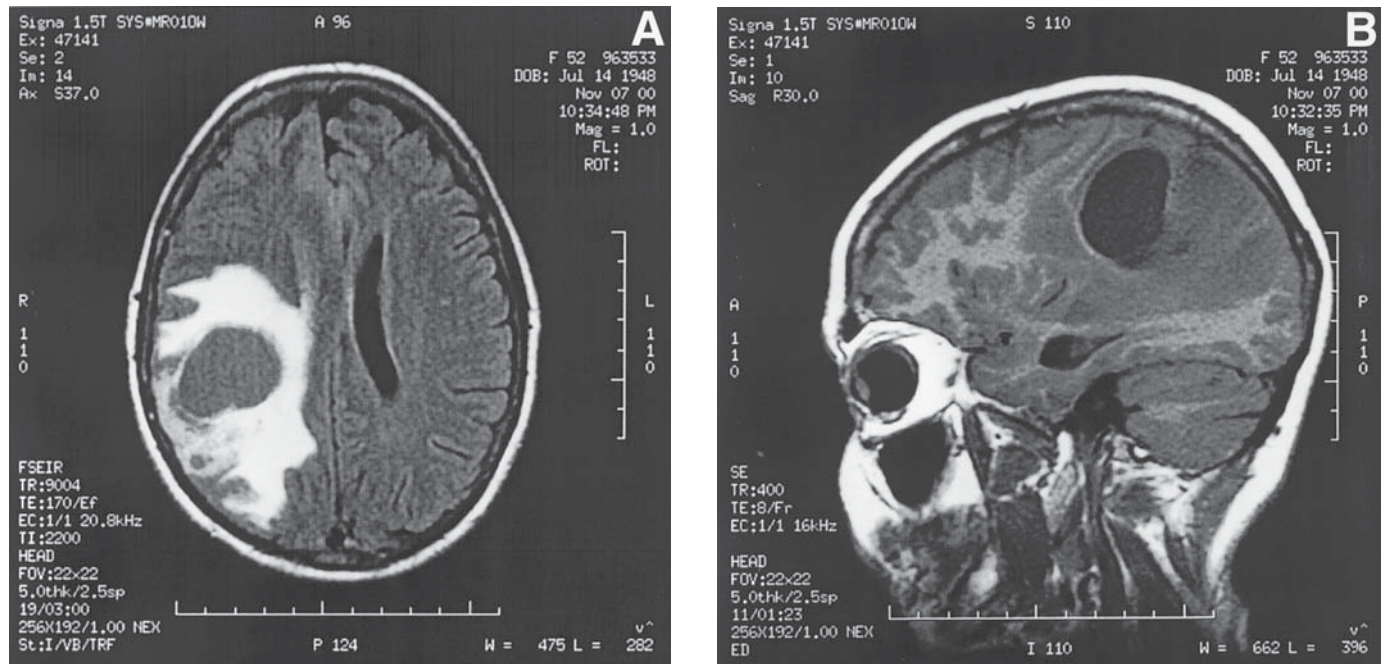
(A)(B). This 52-yr-old woman with a history of migraine headaches for 35 yr that were well-controlled noticed a change in their quality, intensity, duration, and frequency recurrence pattern over a 6-mo period prior to diagnosis. The headaches were mostly unilateral but did occur bilaterally. The frequency increased from a previous average rate of one per month to weekly and then almost daily. She suffered from photophobia and nausea but no vomiting. NSAIDs and anti-migraine medications such as Zomig, which previously controlled the headaches, were no longer effective. MRI showed a large cystic necrotic mass in the right parietal lobe associated with peritumoral edema. At surgery a glioblastoma was resected.
